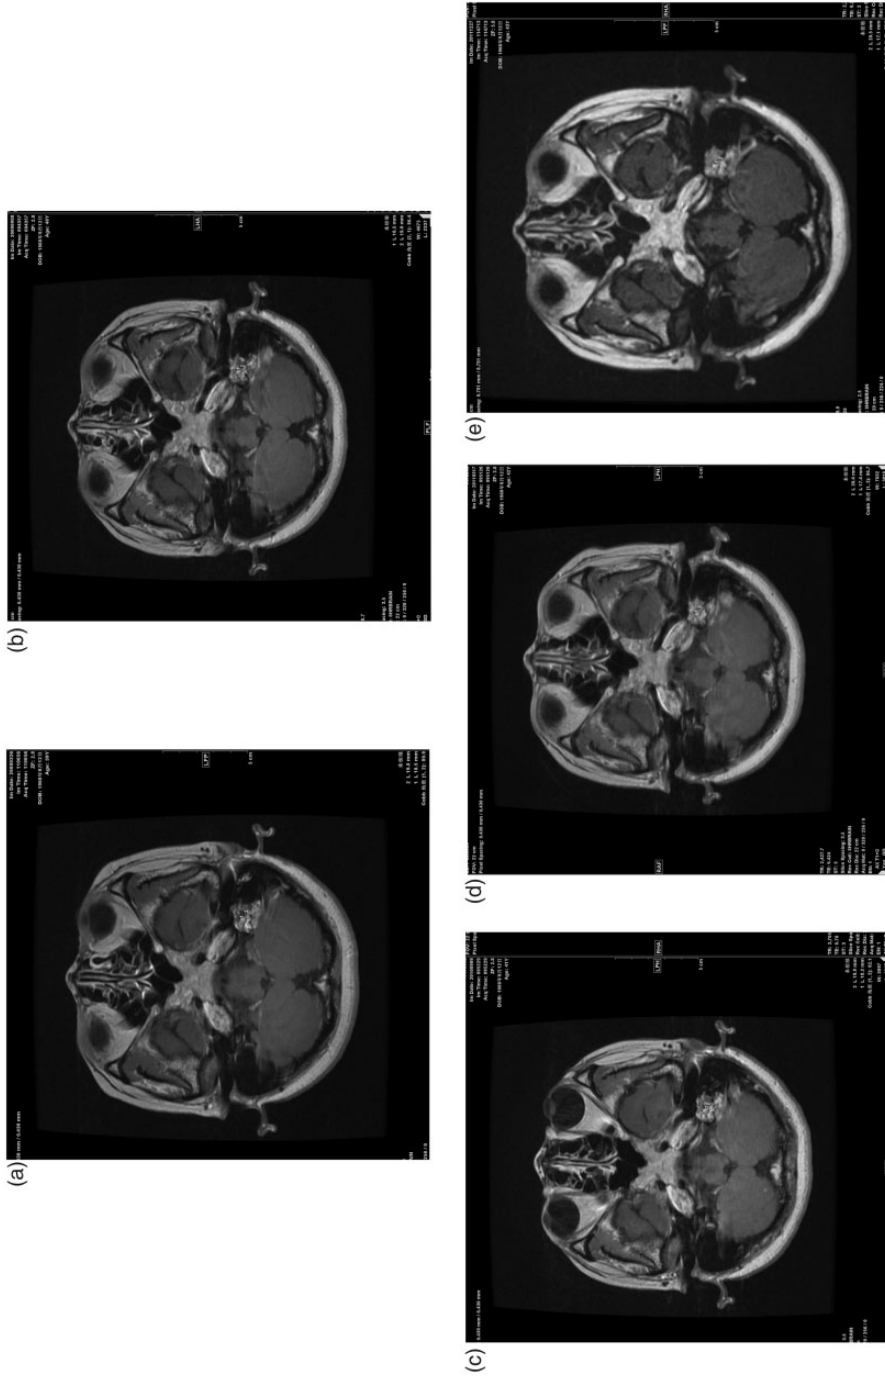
Computed tomography scans showing left endolymphatic sac (arrow) after treatment with clarithromycin on 26 March 2008 (a), 8 September 2009 (b), 9 September 2010 (c), 17 March 2011 (d), and 27 December 2011 (e).
